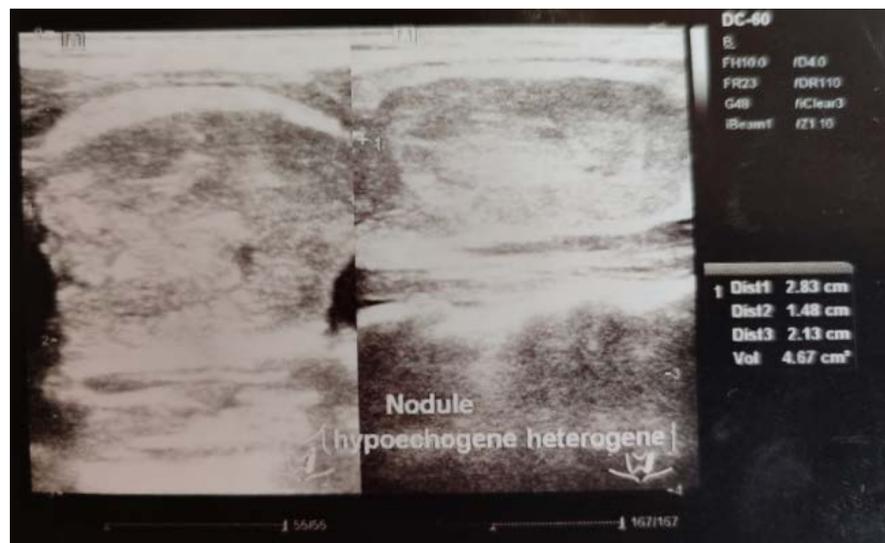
Thyroid ultrasound showing heterogeneous hypoechoic nodule. Source: OSTIE.
